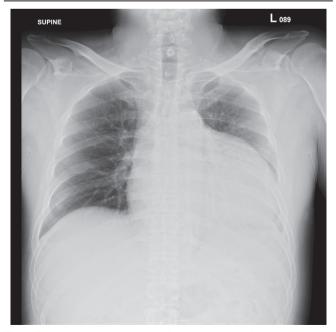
Chest radiograph revealed cardiomegaly in a round-head boot shape.
